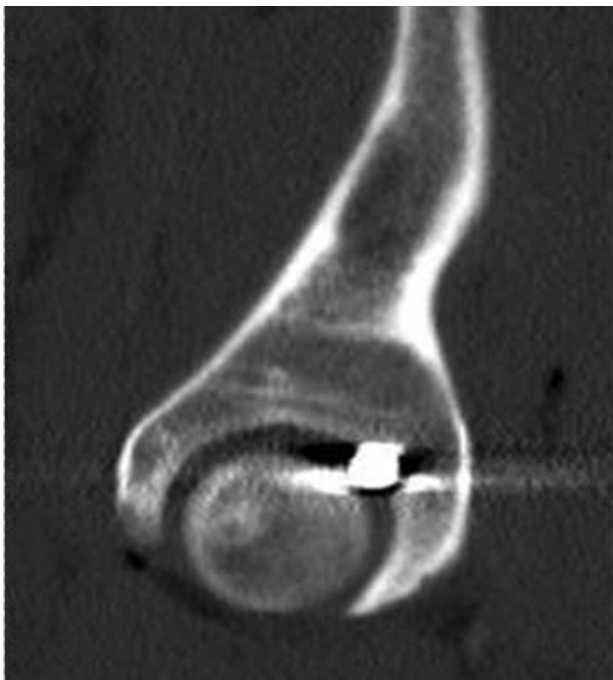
Sagittal view of CT scan.
